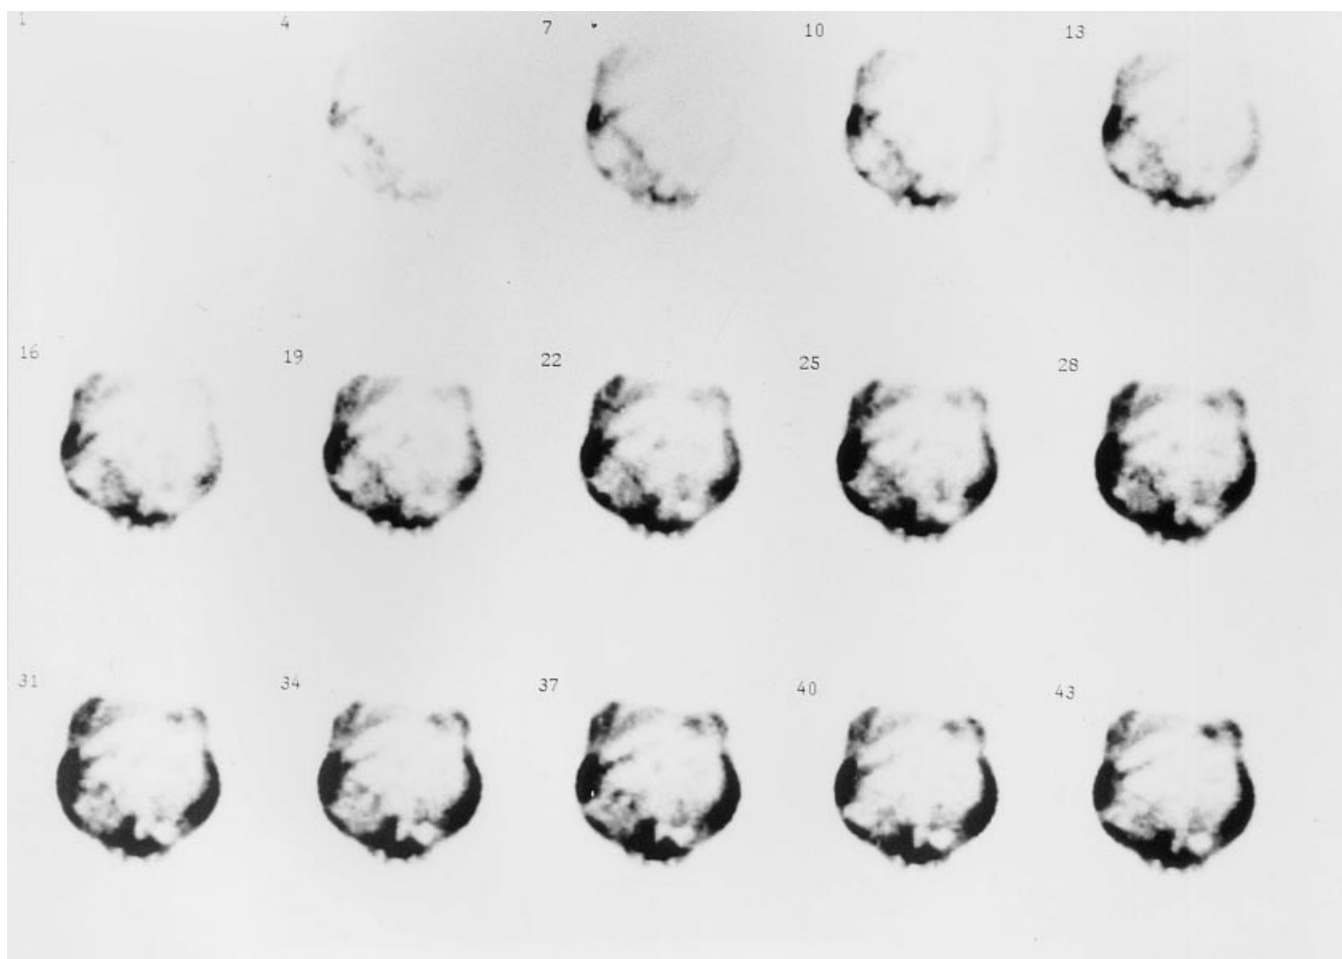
Normal peritoneal scintigraphy scan. Instillation phase images. Free movement of dialysate infusate with radiotracer into paracolic, subdiaphragmatic and pelvic gutters.
